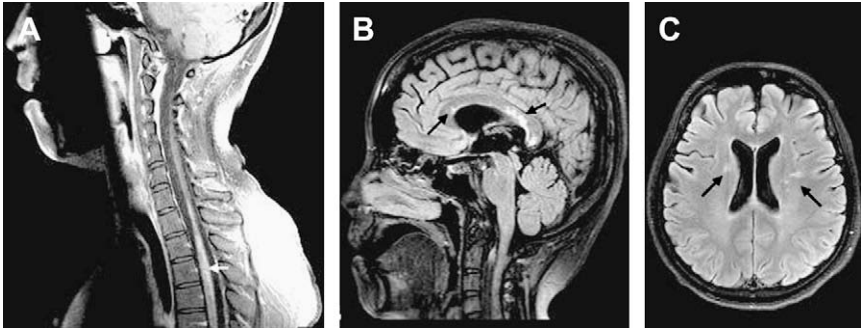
MRI of a 23-year-old woman with pSS and neuromyelitis optica. The patient has a history of bilateral optic neuropathy and has had recurrent episodes of myelitis since age 11. (A) Cervical spine MRI shows a gadolinium-enhancing cord lesion extending from C7-T4 (white arrow). Brain MRI shows T2-hyperintense lesions in the corpus callosum (B) and in the subcortical and periventricular white matter (C) (black arrows).
